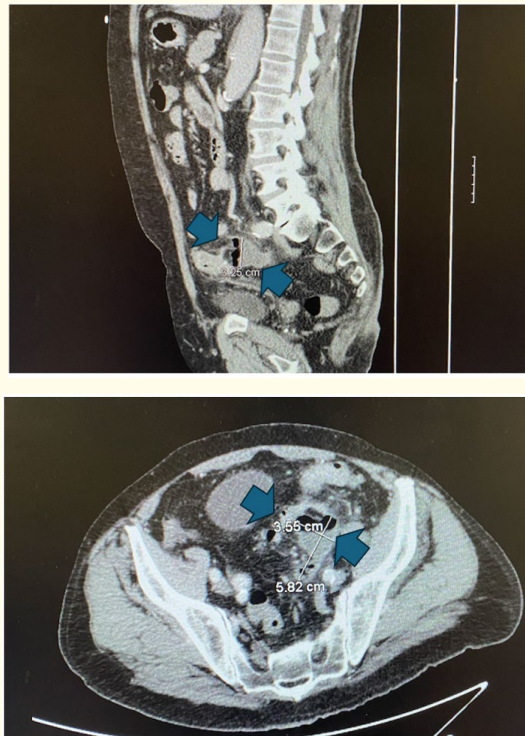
Computed Tomography (CT) scan showing redemonstrated sequela of sigmoid colon diverticulitis with contained perforation along the left side of the colon. Diverticulitis indicated by blue arrows.
